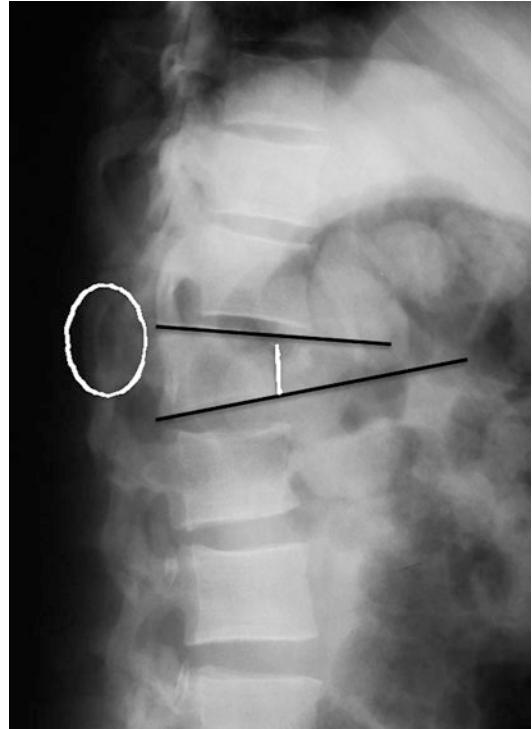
Lateral X-ray after T11–T12 trauma showing kyphosis and loss of vertebral body height and facet disruption (*circle*)
